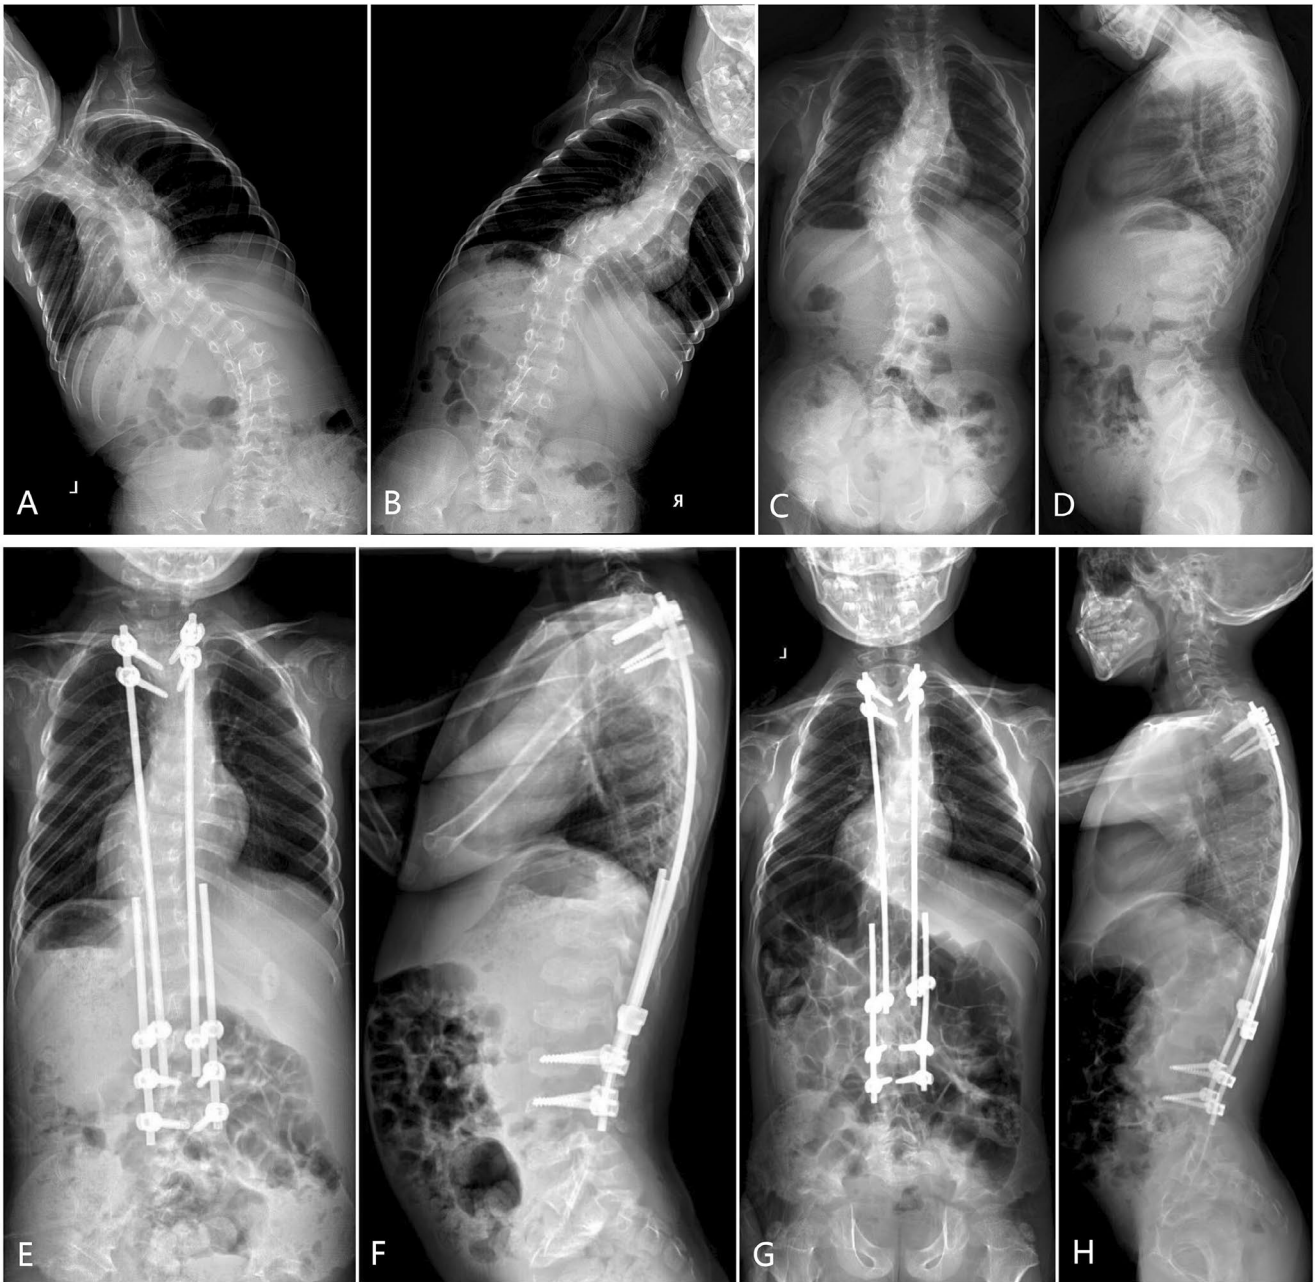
X-rays of Patient 2. (A, D): Preoperative x-rays at the age of 4, including side-bending X-rays (A, B) and whole spine X-rays (C, D), showing a thoracic curve of 50°, a thoracolumbar curve of 32°. (E, F) Immediate postoperative x-rays after the initial surgery. (G, H) X-rays at the latest follow-up after the 3rd growing rod extension.
